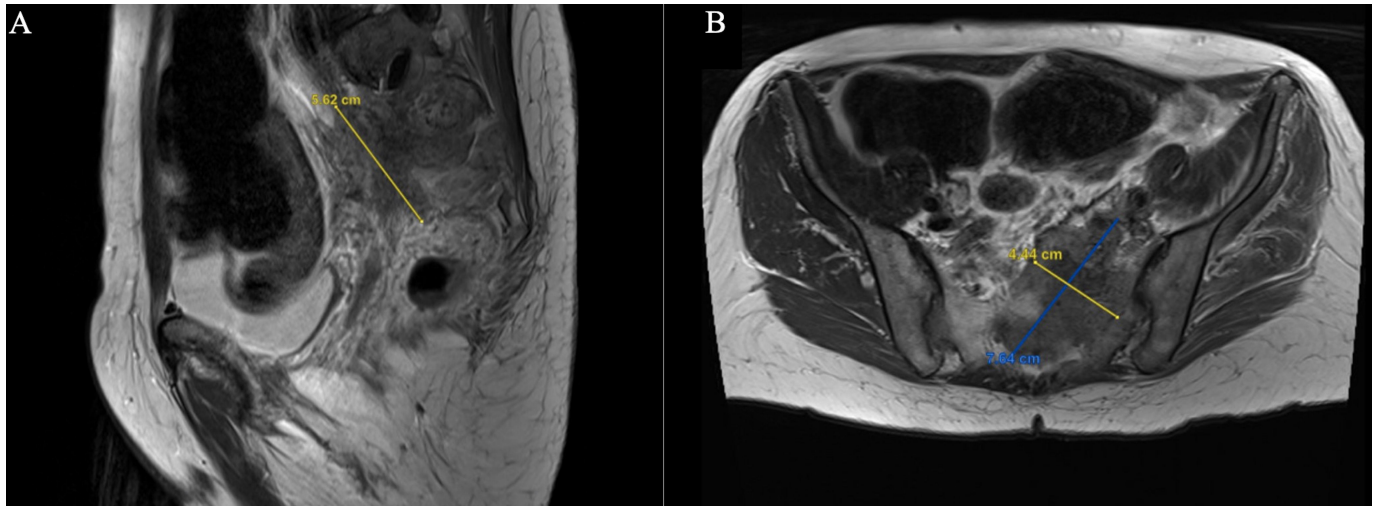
Urgent spinal MRI upon initial presentation to the emergency department. (A) Sagittal view of pelvic MRI demonstrating a 5.6 cm pelvic mass adjacent to the left hemisacrum. (B) Axial view of pelvic MRI with additional dimensions of pre-sacral mass at 4.4 cm and 7.6 cm in maximal diameter.
